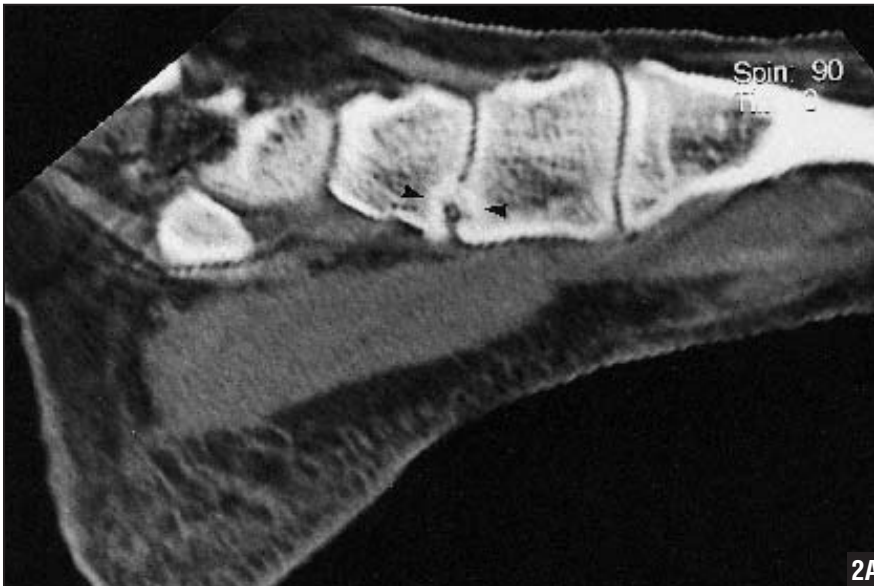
Sagittal reconstruction CT of the right foot showing a coalition in the inferior part of the joint (arrows) (A). Axial reconstruction CT of the right foot showing mild articular narrowing and sclerosis in the first naviculocuneiform joint (arrows) (B).
